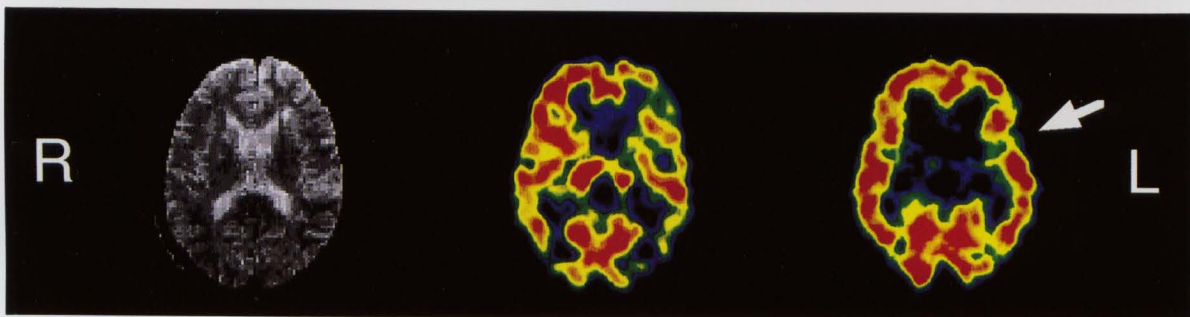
MRI T₂ (left), CBF (center) and BZR (right) images obtained in the chronic phase in a 75-year-old male (patient 5) that classified the patients with a grade of a moderate prognosis. Although decreased CBF distributions were seen in the right cerebellar cortex due to a remote effect and the left frontal cortex (white arrow) due to a hypoperfusion area around the infarction, these distributions were not seen in the BZR images and the defective area containing Wernicke's area was wide. He had Wernicke's aphasia.
